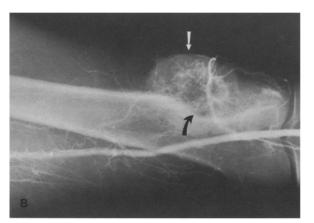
A and B. Case 15. Osteosarcoma. 56-year-old man with swollen right knee. A Sagittal scan immediately proximal to right knee shows soft tissue mass (M) and bone destruction (*curved arrow*). Broad arrow points to normal cortical surface of femur (F). B Angiogram shows large soft tissue mass (*white arrow*) and bone destruction (*curved arrow*) corresponding to features seen ultrasonographically in A. Plain radiographs did not show soft tissue mass. This figure is displayed in same projection on sonogram of A
